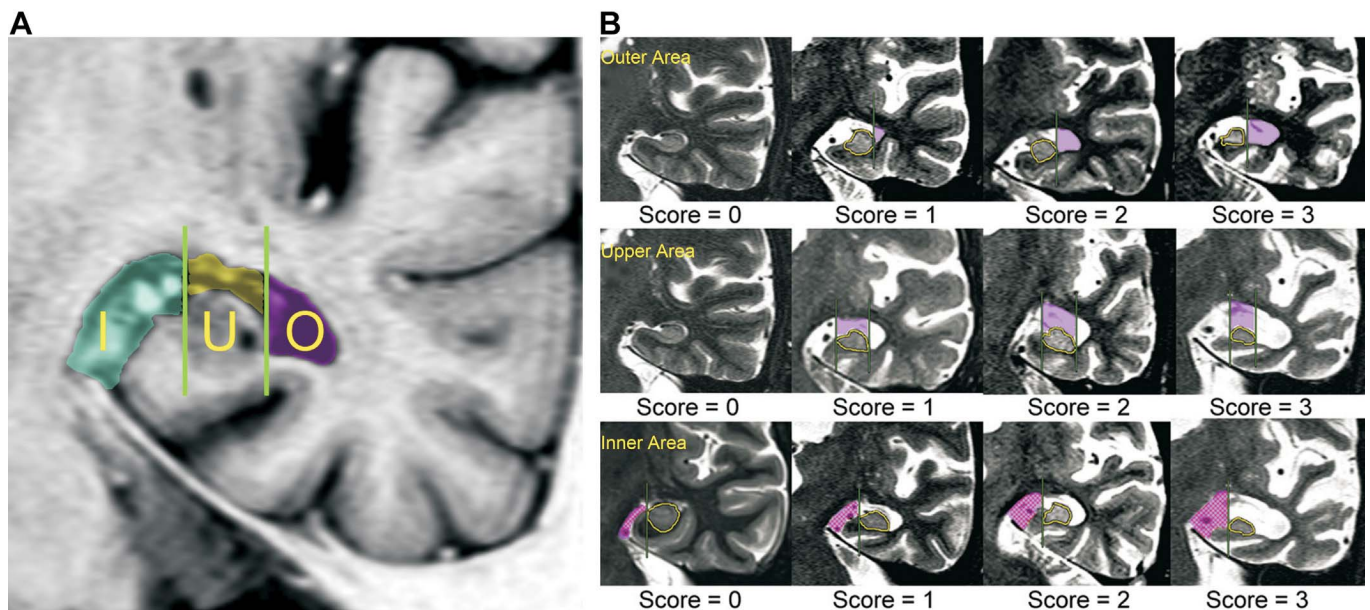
VRS at baseline MR imaging. (A) shows the way to divide the CSF space around the hippocampus into three parts. We draw two perpendicular lines by the inner and outer edge of the left hippocampus, and then we can divide the CSF space into the outer (O), upper (U), and inner (I) areas. (B) shows a representative image of those used to evaluate widening of the CSF space. The outer, upper, and inner areas are arranged from top to bottom. Each row has four images arranged from left to right in accordance with the values of the VRS. Each area for evaluation is painted in pink. The following classifications were used; score 0: lateral (top row) and over (second row) part is slit-like and as narrow as the diameter of the vessels at the inner (bottom row) part; score 1: CSF space is smaller than the hippocampus; score 2: CSF space is nearly the same as the hippocampus; score 3: CSF space is larger than the hippocampus.
